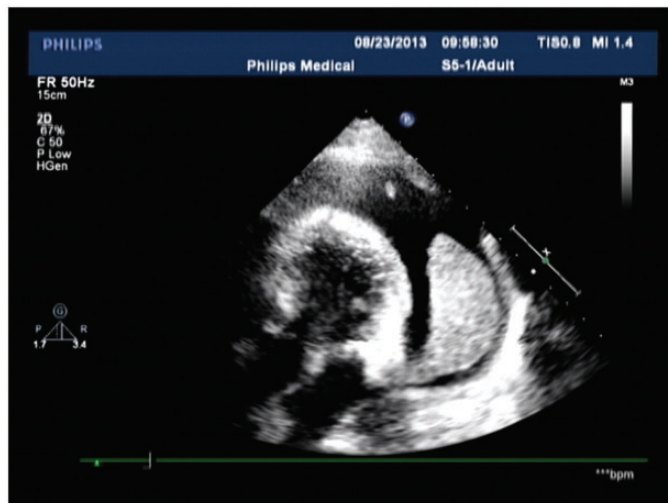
Echocardiographic finding before pericardiectomy. Irregular masses with pericardial effusion persisted.
